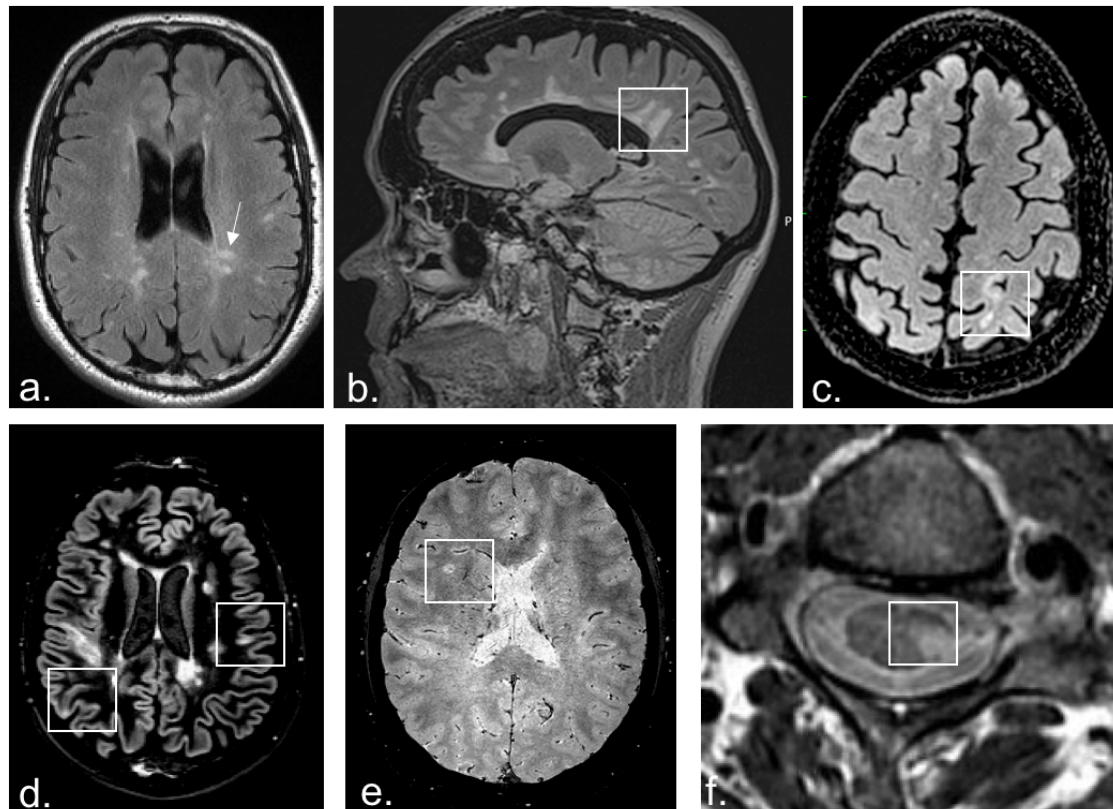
Typical imaging features of multiple sclerosis with conventional MRI and possible differentiating features with non-conventional MRI. a | So-called Dawson fingers (arrow), visible as ovoid periventricular hyperintense lesions perpendicular to the body of the lateral ventricle and/or to the callosal junction, shown in an axial FLAIR image. b | Dawson fingers (box) showing in a sagittal FLAIR image. c | an S-shaped juxtacortical lesion (box) in an axial FLAIR image. d | Cortical lesions (boxes) shown in an axial Double Inversion Recovery (DIR) image. e | The central vein sign, a hypointensity relative to a surrounding hyperintense lesion visible on susceptibility-weighted imaging (an axial T2* image). f | Eccentric short spinal cord lesions that are typical of MS, shown in an axial T2-weighted image
